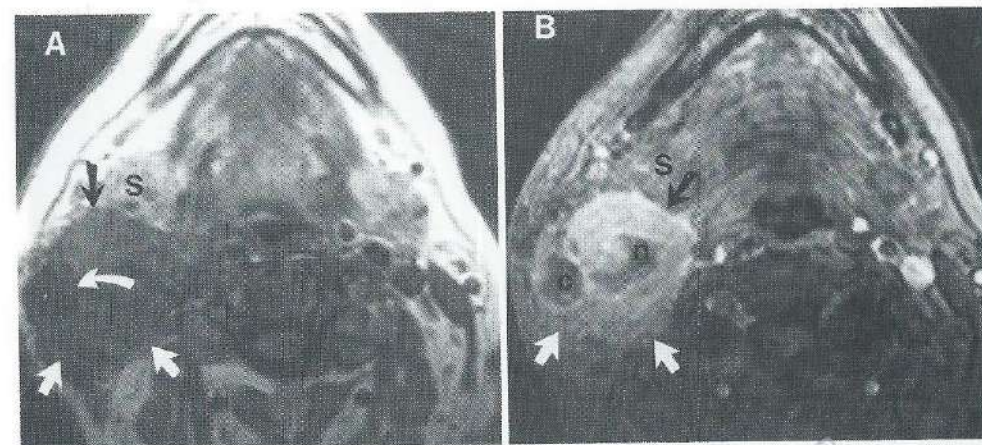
A. T1-weighted SE image of case 22: Right T1N2a tonsillar carcinoma. A 5 cm tumorous mass (straight arrows) in the subgastric region on the right side is depicted with the same signal intensity as surrounding muscles and peripharyngeal tissues. A low signal intensity zone in the mass on the right side is suspected, depicting fluid containing cystic tumor degeneration (curved arrow), S = submandibular gland. B. Gd-DTPA enhanced T1-weighted GE image. The mass (arrows) shows Gd-DTPA uptake and can now be delineated from all surrounding tissues. Two low signal intensity areas in the mass have become apparent. n = necrotic part, c = fluid containing cystic tumor degeneration.
